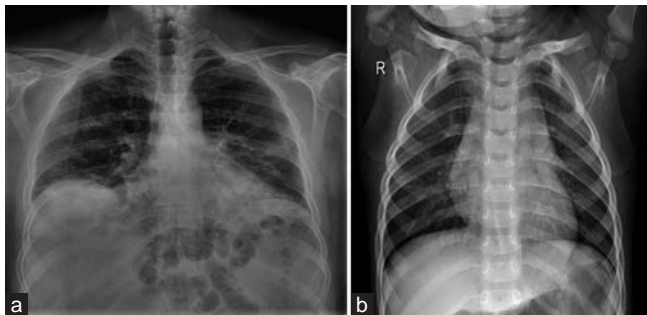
(a) Pneumonia infected. (b) Normal. Examples of X-ray images used in the study, with (a) showing a pneumonia-infected image and (b) displaying a normal image.
